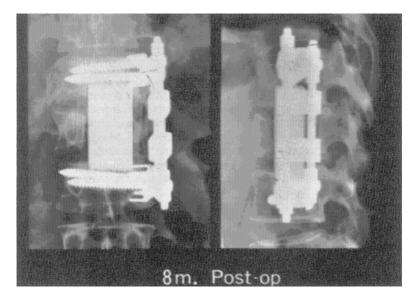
Radiograph of patient with fracture of lumbar vertebra (Ll).
